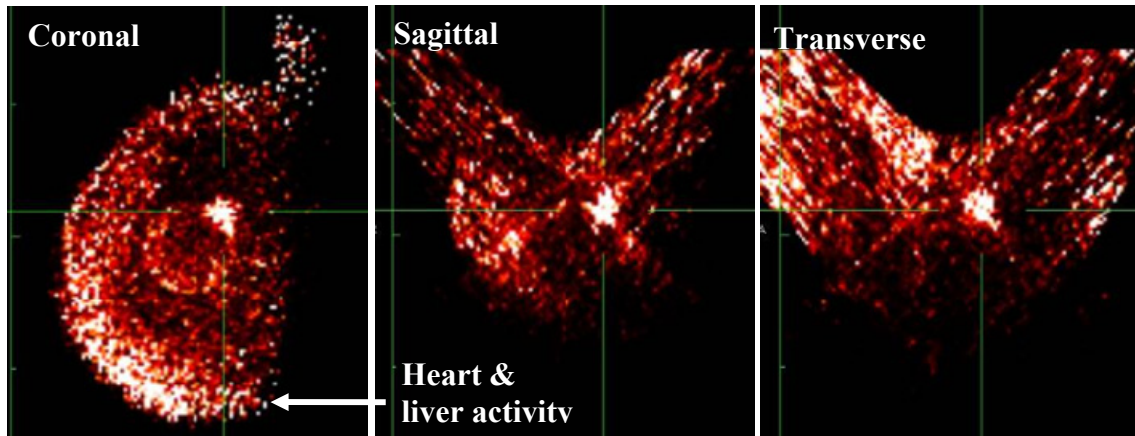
(Left) Coronal, (middle) sagittal and (right) transverse slices of the reconstructed breast. Note the clearly enhanced area of uptake that corresponded with a similar sized area seen on an accompanying MRI scan. Distortion in the breast shape, most readily apparent in the sagittal image, arises from using the tilted parallel beam orbit. The noted streak artifacts, due to uptake in the heart and liver are most readily apparent in the coronal and upper left transverse viewpoint, and indicate the requirement for shielding of the patient bed, as well as application of trajectories that minimize out-of-breast activity.
